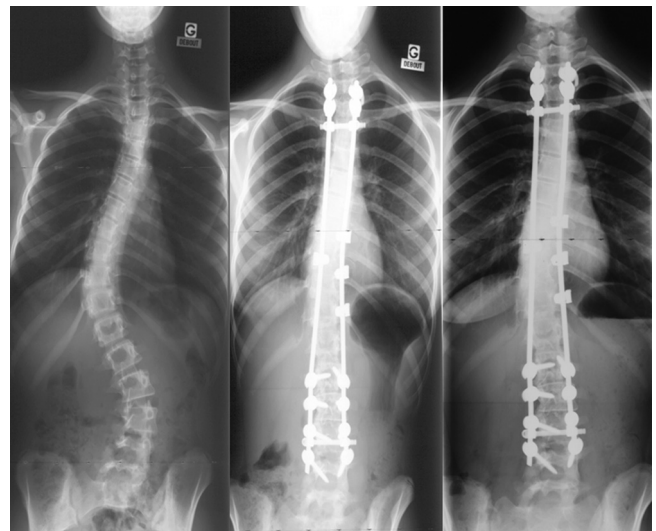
Preoperative, immediate postoperative and latest frontal radiographs of a 15-year-old patient who was operated using bioglass. Solid fusion was obtained at 32 months postoperative.
